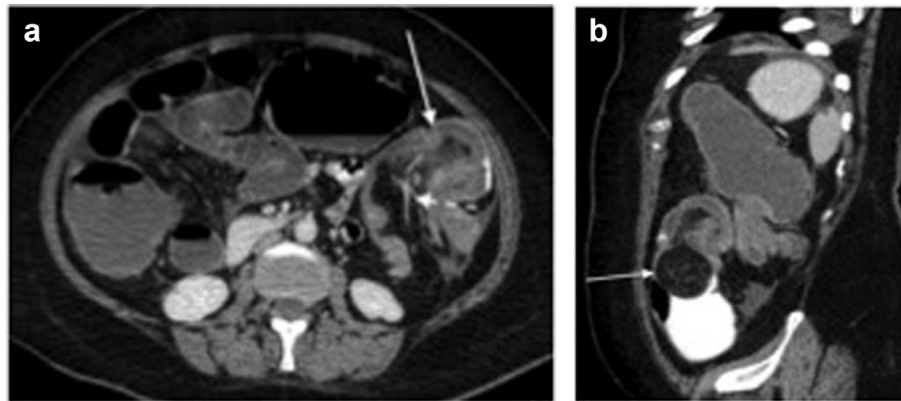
(a) IV and rectal contrast-enhanced CT scan of the abdomen demonstrates findings of large bowel intussusception (solid arrow) with invaginated mesenteric fat and vessels (dashed arrow). (b) IV and rectal contrast-enhanced CT, sagittal reconstruction demonstrates an intraluminal mass with fat attenuation (arrow).
